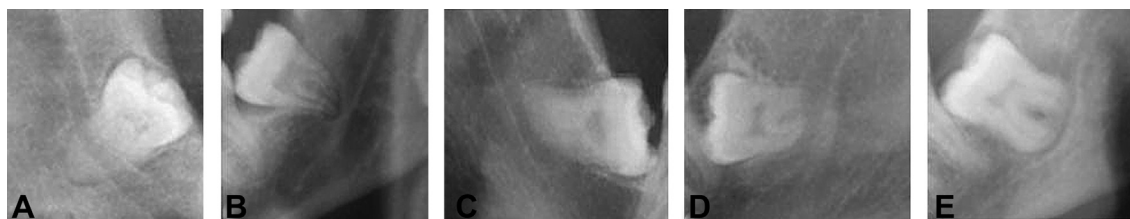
Five radiographic markers on panoramic radiography: (A) superimposition, (B) increased radiolucency, (C) interruption of the radiopaque border, (D) diversion of the mandibular canal, and (E) narrowing of the mandibular canal.
